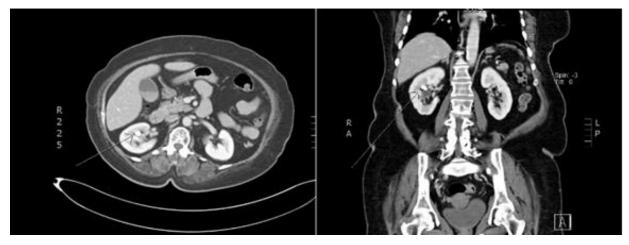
The SPECT-CT showed non-specific tracer uptake in known right renal stone (arrow).
